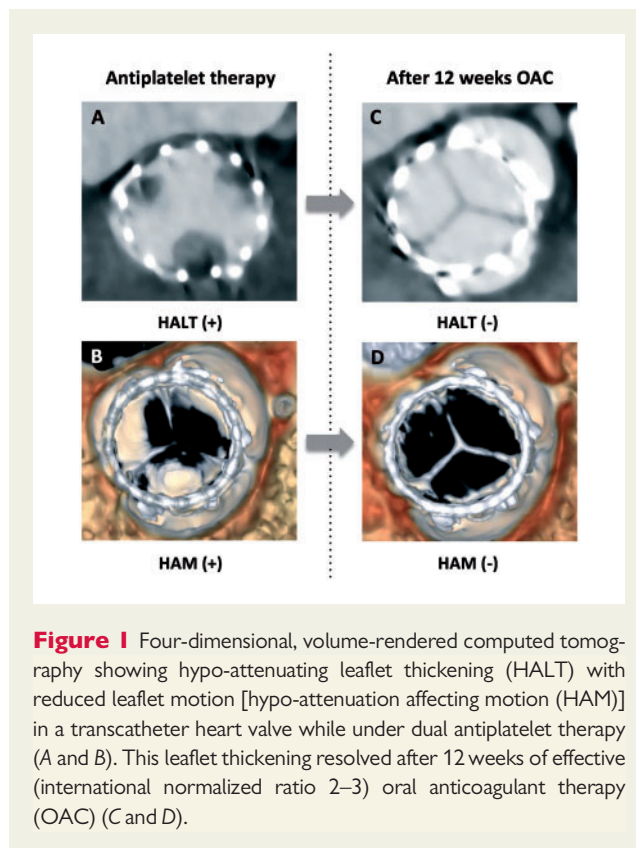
Four-dimensional, volume-rendered computed tomography showing hypo-attenuating leaflet thickening (HALT) with reduced leaflet motion [hypo-attenuation affecting motion (HAM)] in a transcatheter heart valve while under dual antiplatelet therapy (A and B). This leaflet thickening resolved after 12 weeks of effective (international normalized ratio 2–3) oral anticoagulant therapy (OAC) (C and D).
